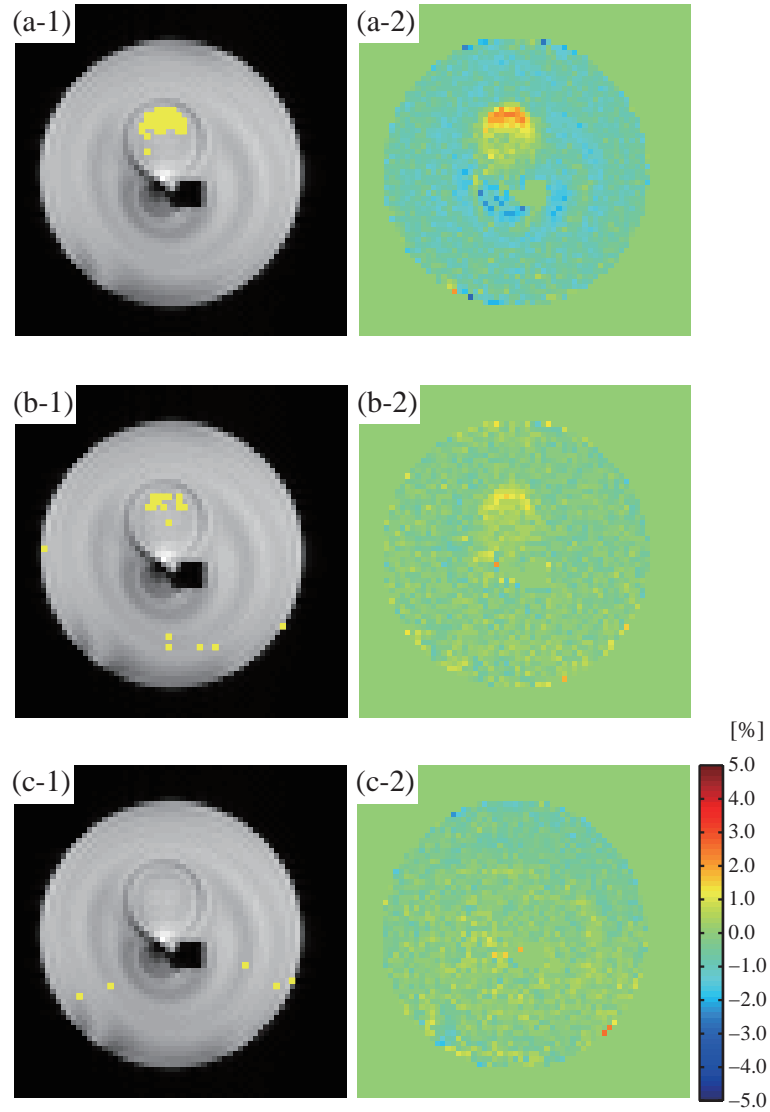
(Left column) MR images with pixels indicating significant differences. (Right column) Percent signal differences between MR images with and without on-resonant oscillating magnetic fields. Amplitude of oscillating magnetic fields B_m were 314.0 (a), 157.0 (b) and 31.4 (c) pT.
